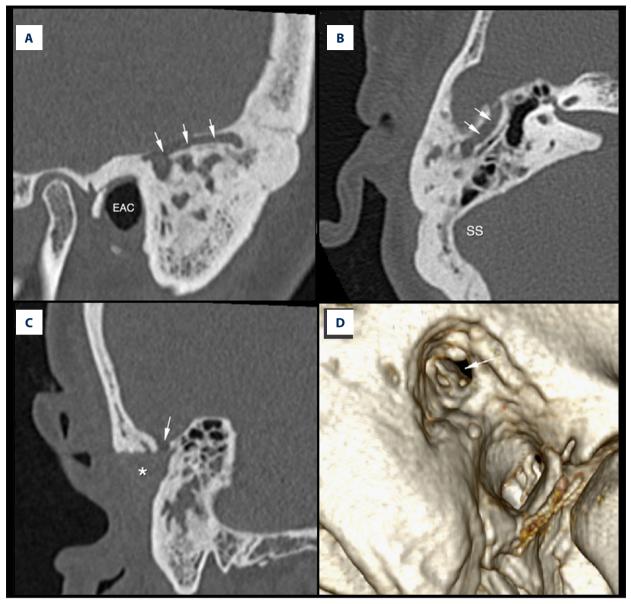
Multiplanar reformatting reconstructions of temporal bone computed tomography scan of a 38-year-old female with chronic otitis media and persistent petrosquamosal sinus (PSS) in the bony canal (white arrows). The axial plane (A) shows a sclerotic mastoid with a half-moon type of sigmoid sinus and a large PSS canal (white arrows). In the coronal plane (B), the bony deficit of the external auditory canal and mastoid after canal-wall-down surgery necessitated by cholesteatoma and a PSS bony canal (white arrow) are shown. In the sagittal plane (C), the PSS bony canal (white arrows) running through the anterior part of the temporal bone is shown.
